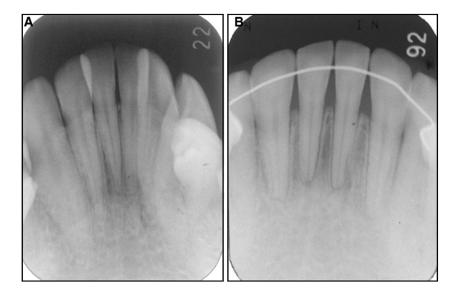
Comparison of dental radiographs of the mandibular anterior teeth: A, pretreatment; B, post-treatment.
